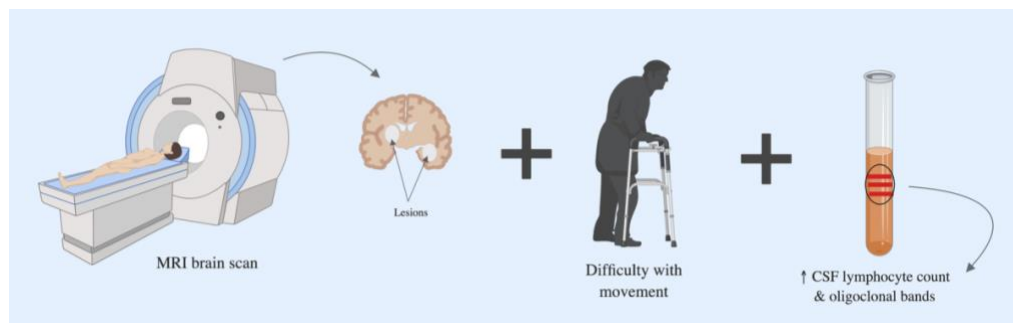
Diagnosis of MS is made by evaluating three factors: neurological symptoms (ex. motor impairment), the presence of CNS lesions on MRI brain scans and laboratory testing (CSF oligoclonal bands).
